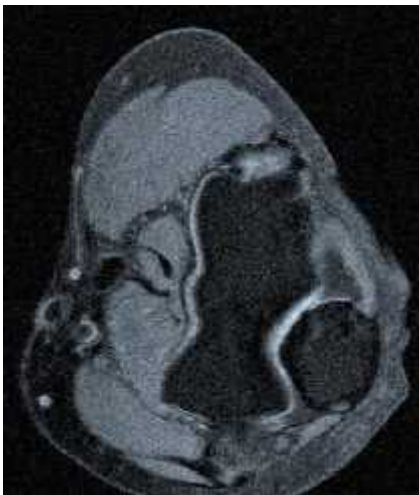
Axial T1 MRI Elbow
